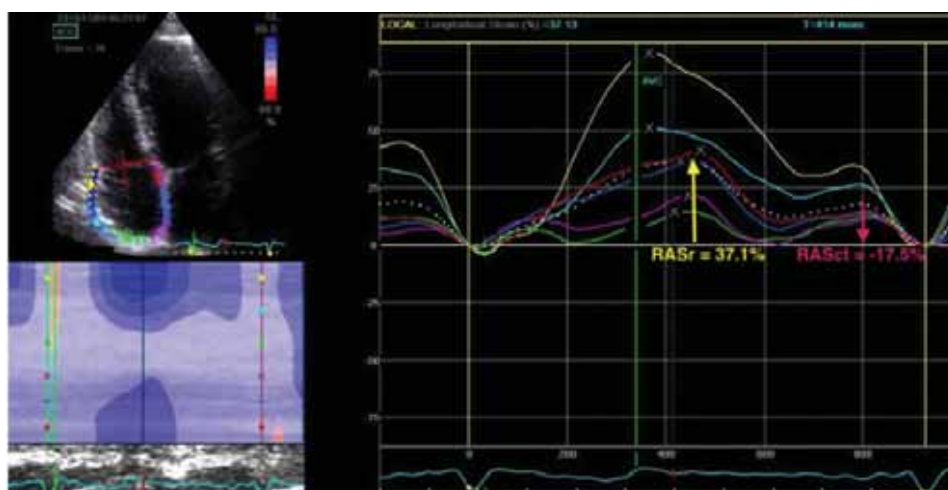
Measurement of RA strain using STE in the apical 4-chamber view. The six colored curves represent strain curves for six different segments of the RA. The dotted curve represents the average strain which was used to measure RAS_r (having a positive value) and RAS_{ct} (having a negative value)
